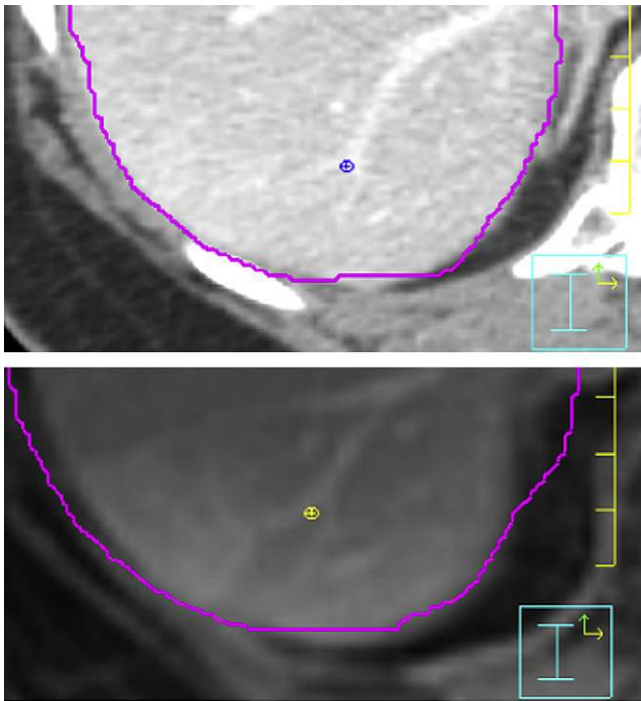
Example of the corresponding vessel bifurcations identified in the exhale computed tomography (top) and magnetic resonance (bottom) images. The liver (purple) contoured on the exhale image is overlaid onto the magnetic resonance image.
